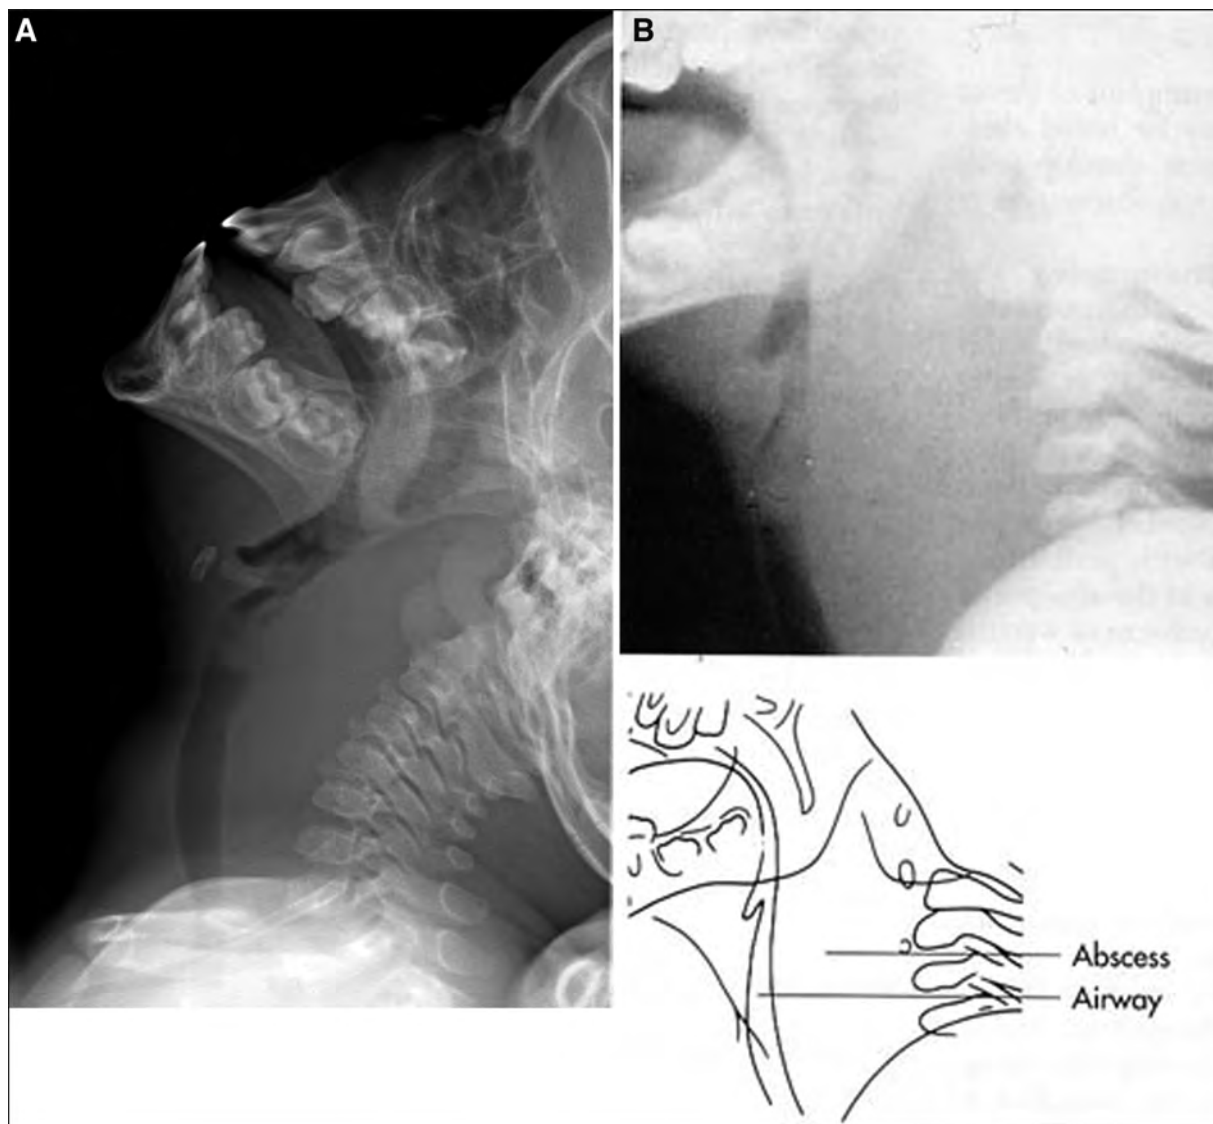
Lateral neck radiograph showing abnormally increased thickness of the prevertebral soft tissue (A and B) and loss of the normal cervical lordosis (B). (A) Department of Radiology, Miami Children's Hospital, FL. (B) Reprinted with permission from Zitelli BJ, Davies HW, eds. In: *Atlas of Pediatric Physical Diagnosis*. 5th ed. Philadelphia, PA: Mosby/Elsevier; 2007.
